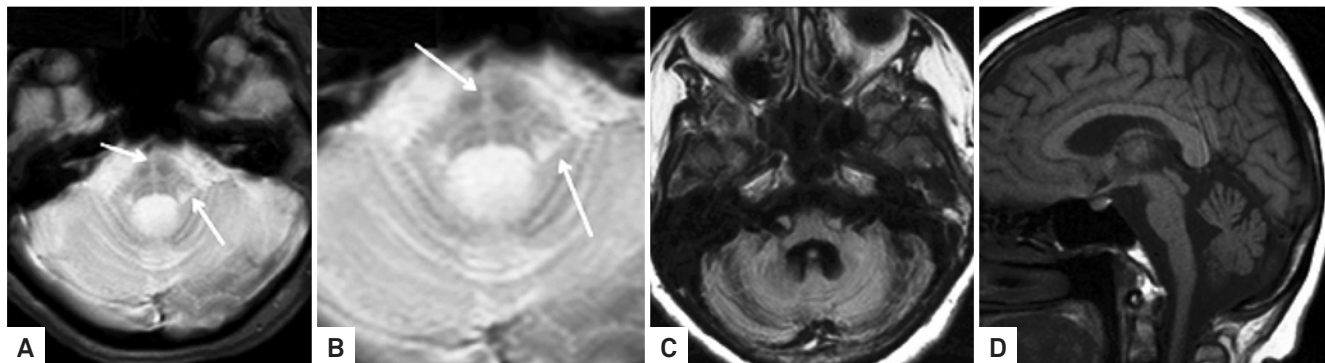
Axial T2* weighted brain MRI (A and B) showing the “hot cross bun” sign in the pons and cerebellar and brainstem atrophy. Wallerian degeneration was also observed, characterized by marked hyperintensity in the pontocerebellar fibers (arrow). Axial fluid-attenuated inversion recovery (FLAIR) (C) and sagittal T1 (D) reinforce olivopontocerebellar atrophy, but no hyperintensity was observed in the pontocerebellar fibers. Supratentorial images showed no atrophy or abnormal sign in the basal ganglia.
